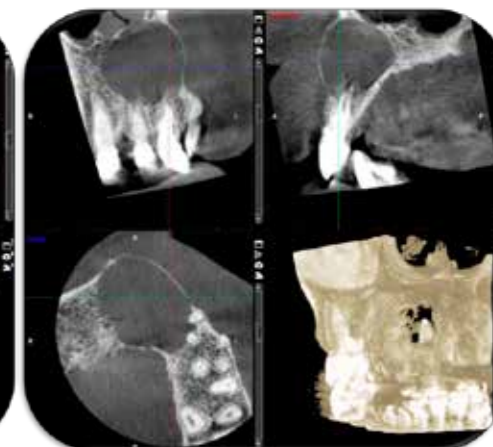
CBCT scans of the upper left anterior region.
